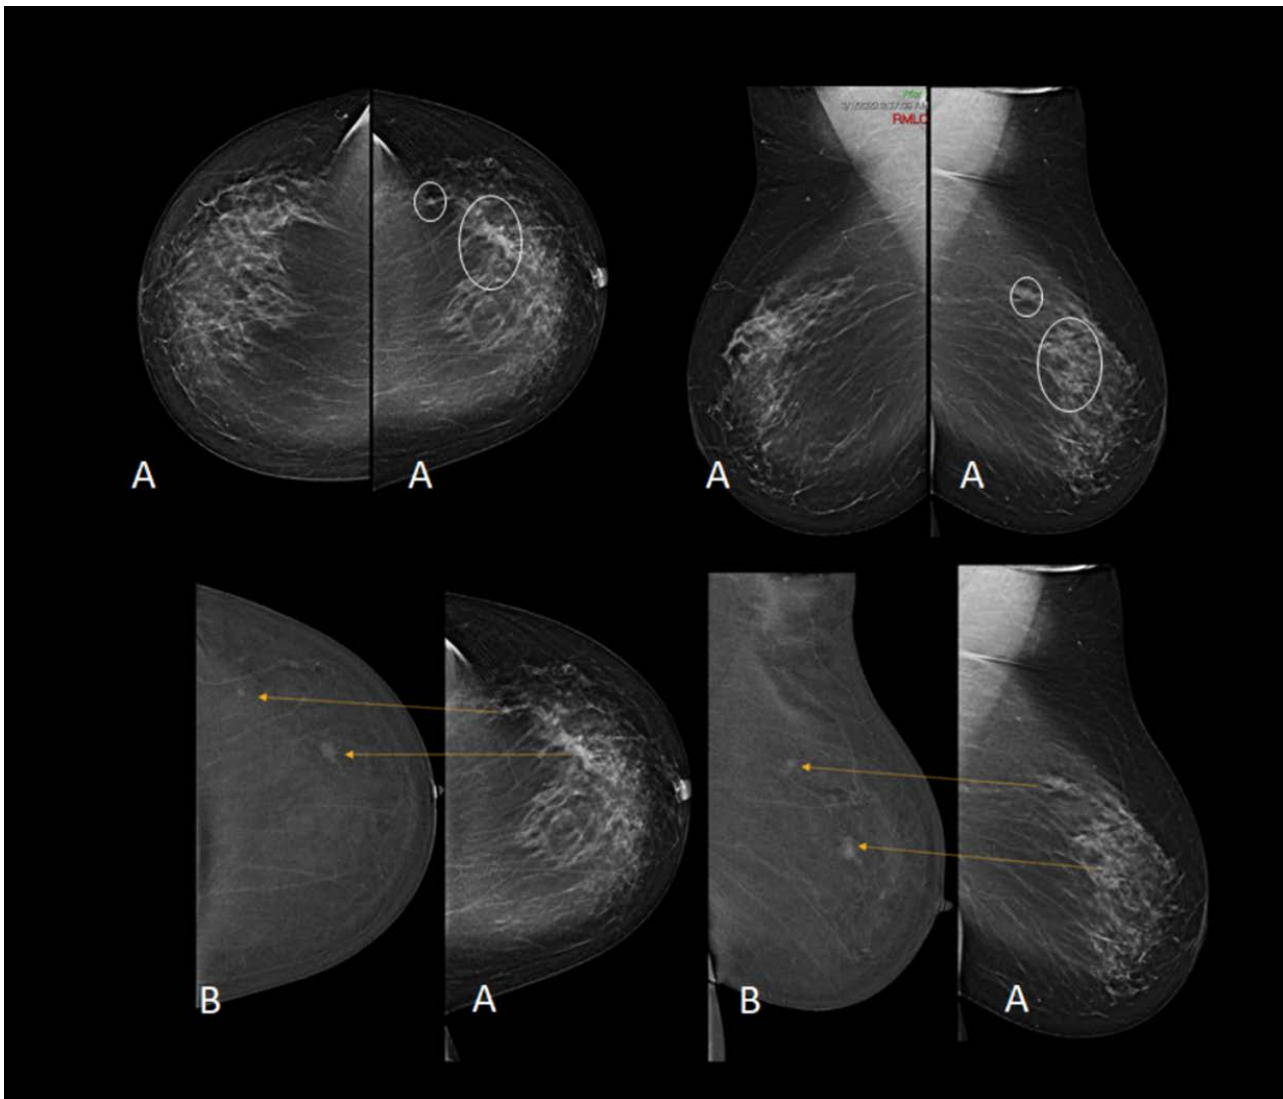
A) Digital mammography with tomosynthesis demonstrates architectural distortion in the upper lateral quadrant of the left breast, not depictable by ultrasound. A zone of focal asymmetry is also present in the axillary tail of the same breast (marked by a circle). B) Contrast-enhanced mammography demonstrates contrast enhancement of both mammographically detected lesions (yellow arrows). Since the lesions were not visualized by ultrasound, a vacuum-assisted biopsy was performed confirming invasive ductal breast cancer no special type grade 2.
